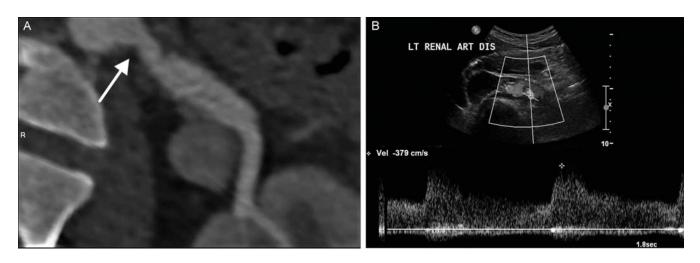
(a) CT angiogram demonstrating severe proximal left renal artery stenosis (arrow). (b) Doppler waveforms study of the same artery showing high velocities (3.8 m/s) indicating severe RAS. CT angiogram, computed tomography angiogram; RAS, renal artery stenosis.
